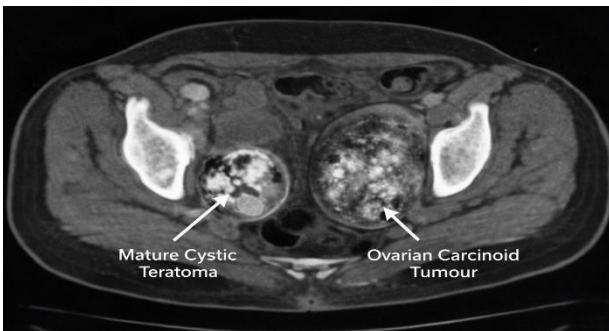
Contrast-enhanced CT (axial section) of the pelvis demonstrating bilateral ovarian lesions.
